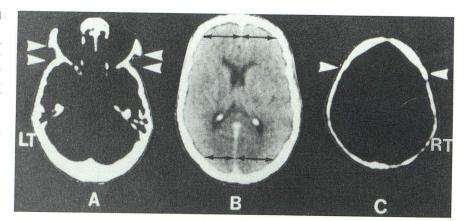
Axial CT scans of a 70-year-old left-handed man.
